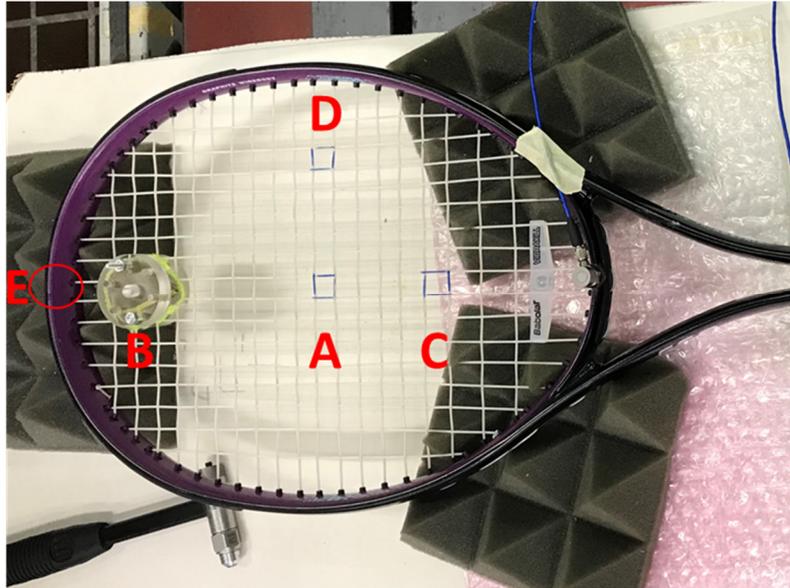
Solicitation points. Distance from the closest edge to the frame: $DT = 5\text{cm}$, $AT = 12.5\text{cm}$, $BT = 7.5\text{cm}$, $CT = 10\text{cm}$ (T indicates the internal edge of the frame).
